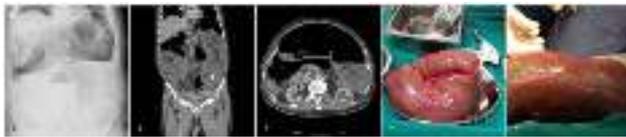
A: Dilated colon segments on abdominal X-ray; B/C: SV observed on coronal and axial cross-section with CT; D/E: Postoperative view of resected sigmoid colon.
